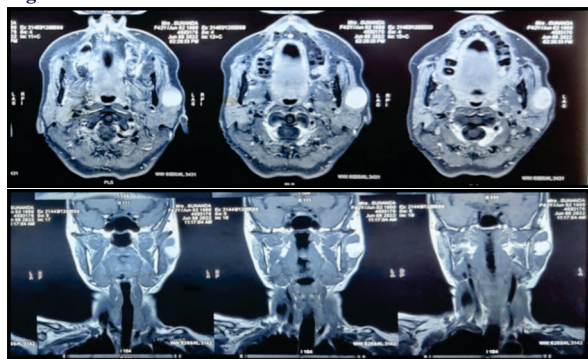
MRI with contrast, a. axial view, b. coronal view.
